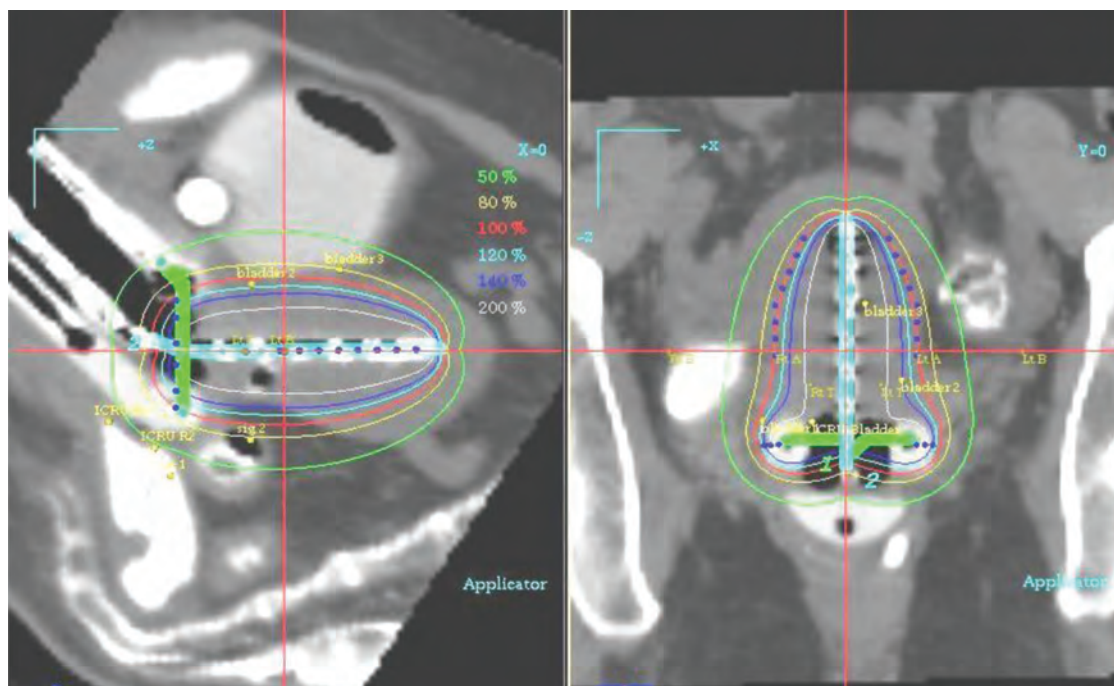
Computed tomography-based computerized treatment planning with the applicator in place, with associated isodoses in sagittal and coronal planes.
